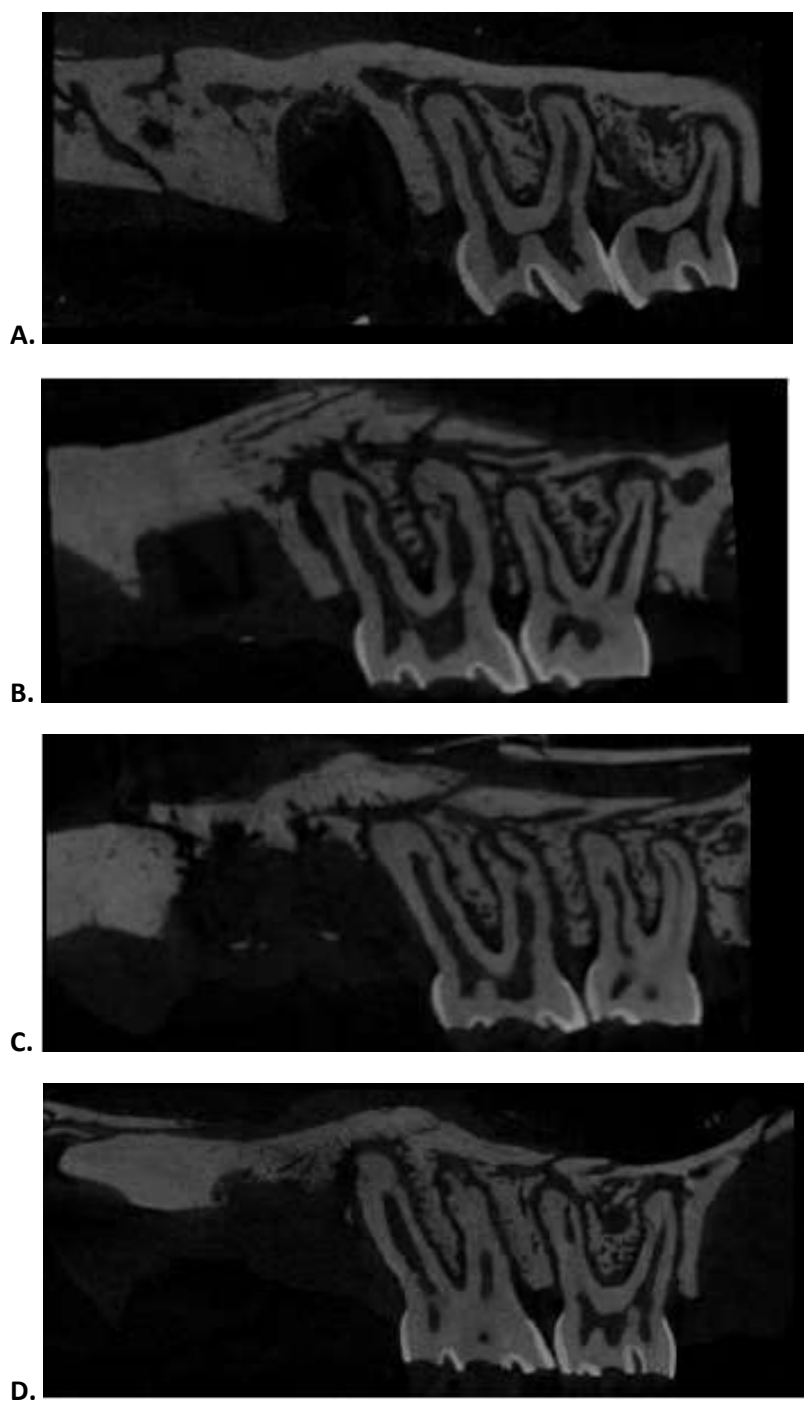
Representative μ CT for interproximal bone loss from Part 1.
